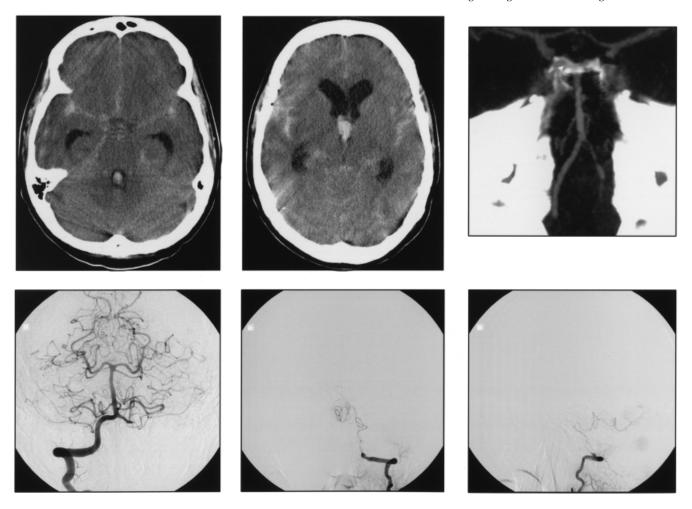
Subarachnoid haemorrhage from dissection of a vertebral artery. CT angiogram on the day of admission shows irregular narrowing of the left vertebral artery. Intra-arterial angiography 1 week later shows absence of retrograde filling on injection of the right vertebral artery (lower left panel) and a string sign on injection of the left vertebral artery (lower centre and right panels).
